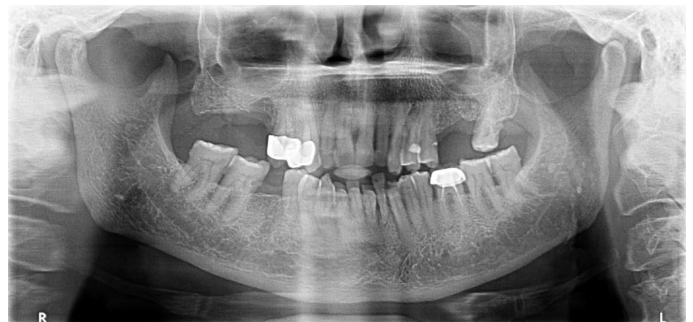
Radiographic examination: without bone involvement.
